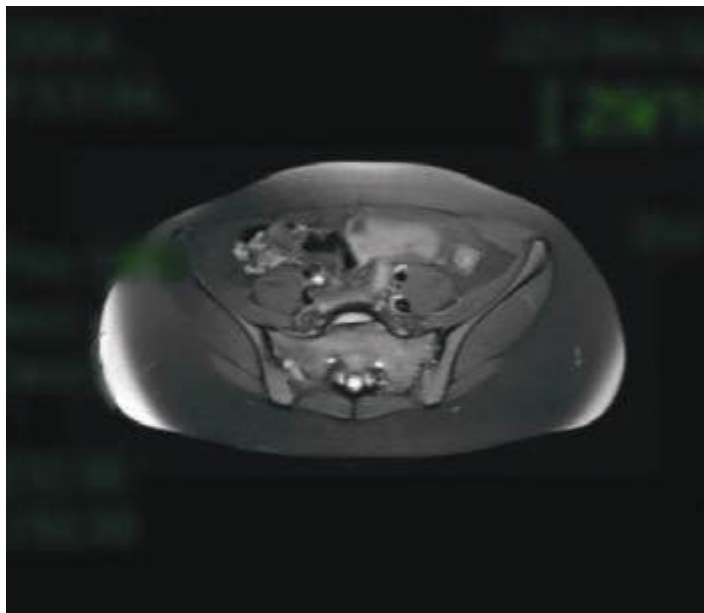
Follow-up axial MRI at the level of the sacroiliac joints exhibits preserved joint morphology and absence of inflammatory changes, consistent with complete regression of previously observed sacroiliitis.
